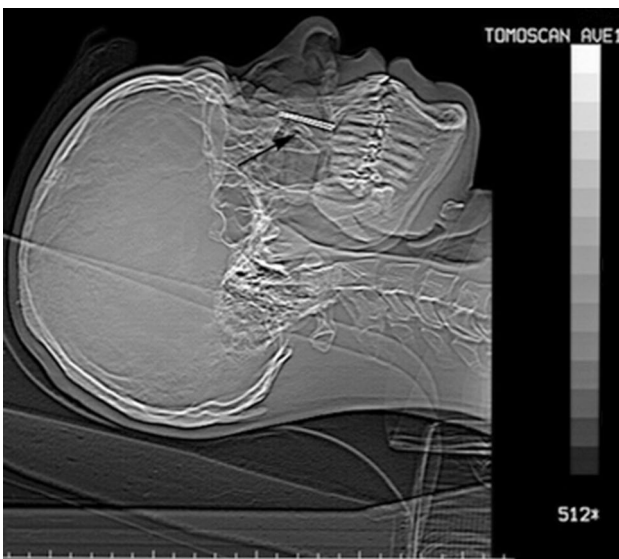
Metal foreign bodies (two nails) embedded behind anterior wall of right maxillary sinus seen on lateral cranial digital X-ray (black arrow).
